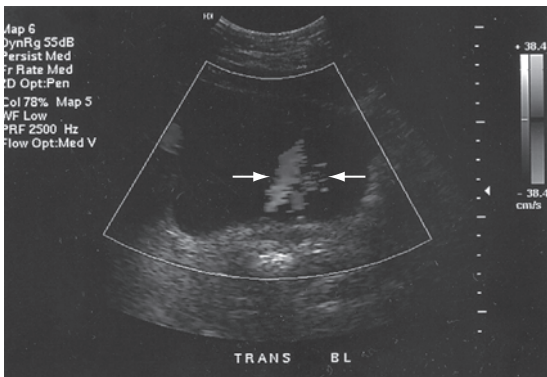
Ureteral jets. Color Doppler demonstrates ureteral jets (arrows) within the bladder indicating nonobstruction of the ureters (see color inserts).
